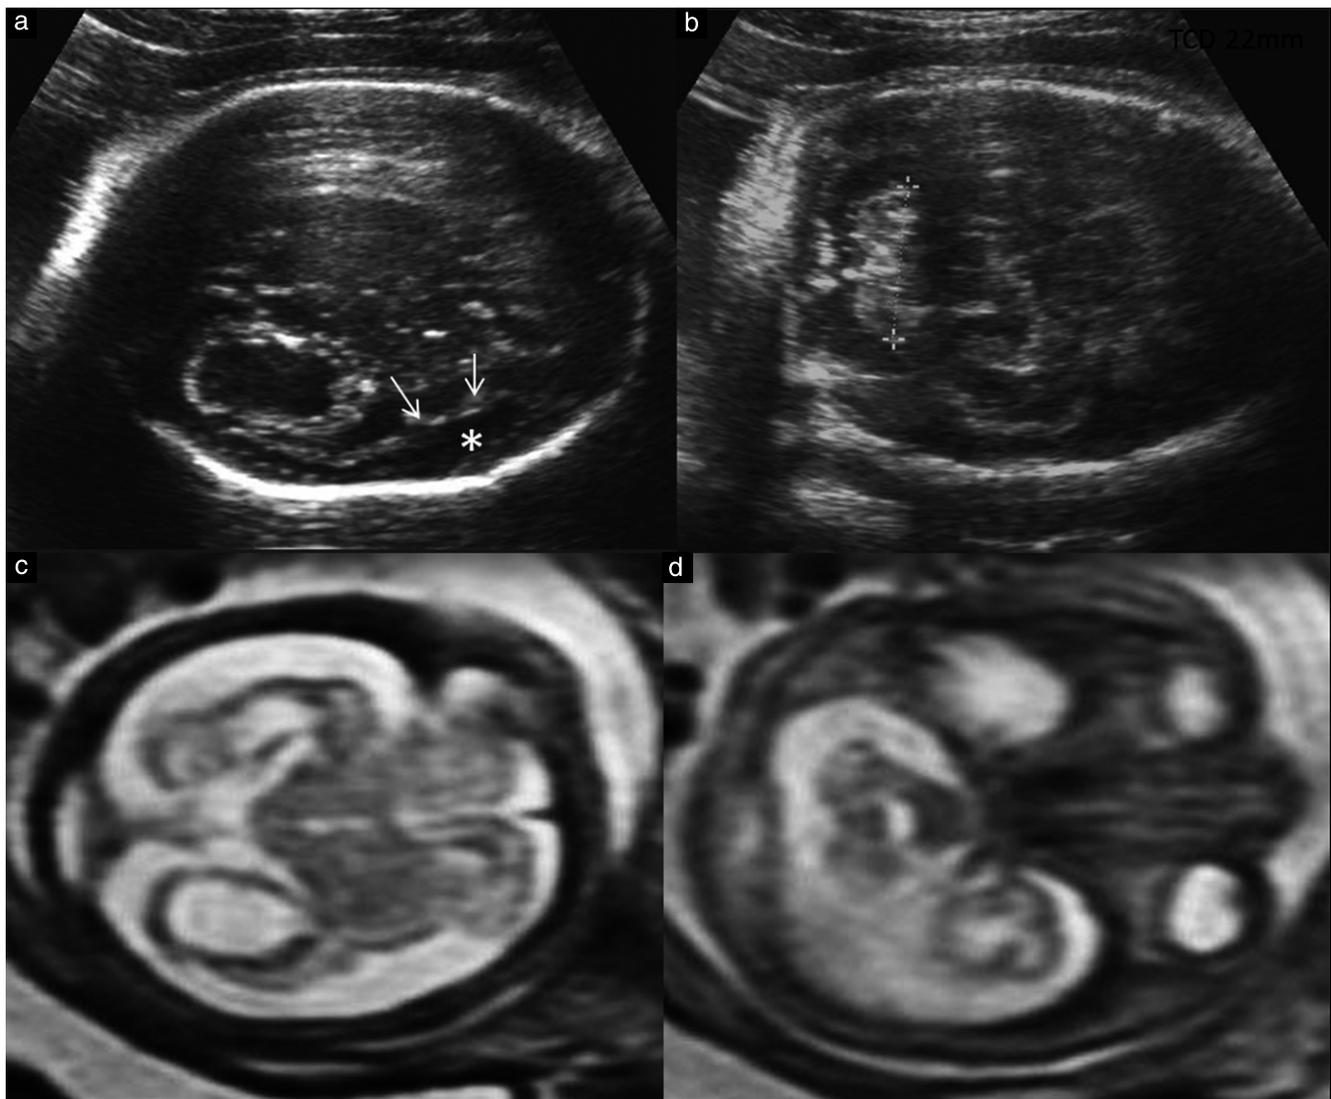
Fetal imaging in a patient referred at 29 gestational weeks due to unexplained ventriculomegaly, associated with significant reduction in cephalic biometry (head circumference corresponded to the 50th percentile at 25 weeks, equivalent to a decrease of between -3 SD and -4 SD). (a) Axial supratentorial sonographic image showing an echogenic periventricular band, echogenic foci suggestive of calcifications, an abnormal largely open Sylvian fissure (arrows) and increased pericerebral space (*). (c) Global increased pericerebral space was confirmed on T2-weighted magnetic resonance imaging in the axial plane, which also showed thinning of the parenchymal cerebral mantle more clearly. Axial sonographic (b) and T2-weighted magnetic resonance infratentorial (d) images demonstrating a major decrease in transverse cerebellar diameter (22 mm), suggestive of severe cerebellar hypoplasia. The combination of an ‘infectious clastic pattern’ with increased pericerebral space, diffuse cortical dysplasia (polymicrogyria) and cerebellar hypoplasia was highly suggestive of encephaloclastic cytomegalovirus fetopathy, which was confirmed by the biological work-up.
